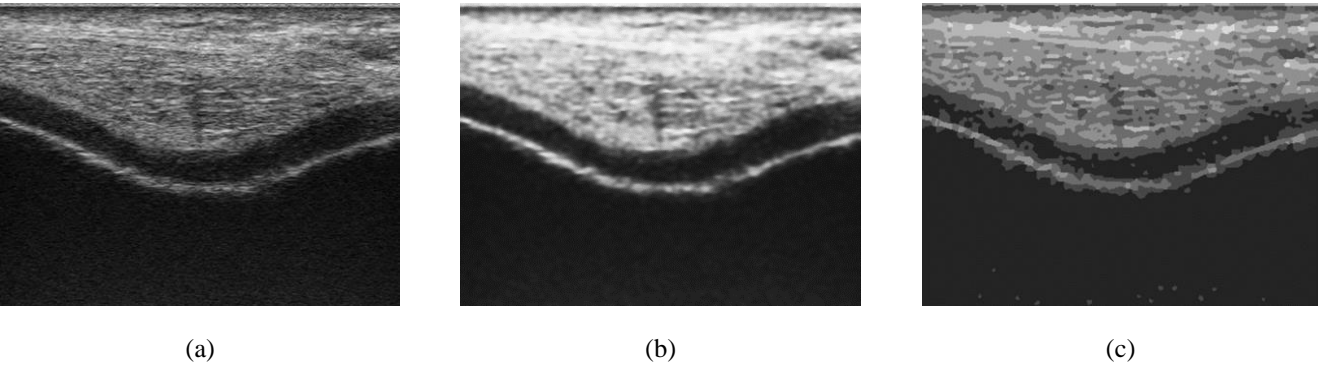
(a) An original cartilage ultrasound image, (b) the image after noise removal and contrast enhancement, and (c) the MRF segmentation with  $N_L = 8$ .
